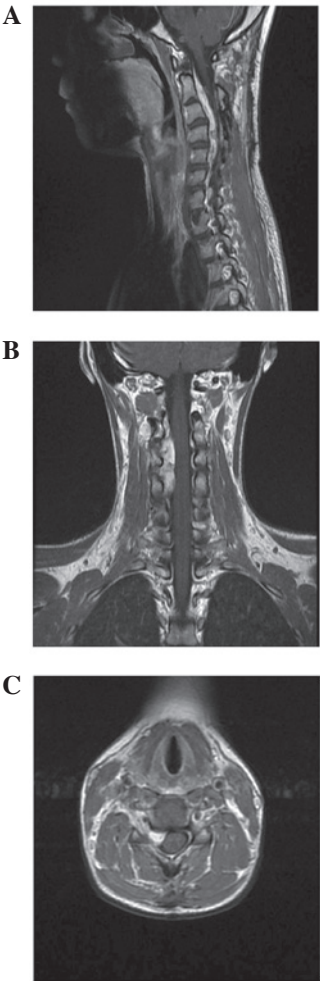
Gadolinium-enhanced (A) sagittal, (B) coronal, and (C) axial T1-weighted magnetic resonance images demonstrating an extradural well-defined regrown tumor with marked enhancement, compressing the cord ventrally at the C2-5 level and involving the right paraspinal region and adjacent neural foramen.
